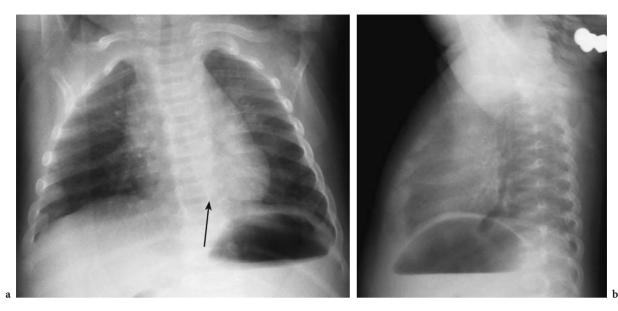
Air outlining a normal esophagus. AP (a) and lateral chest (b) radiographs of a crying infant with an air-filled esophagus (*arrow*)
